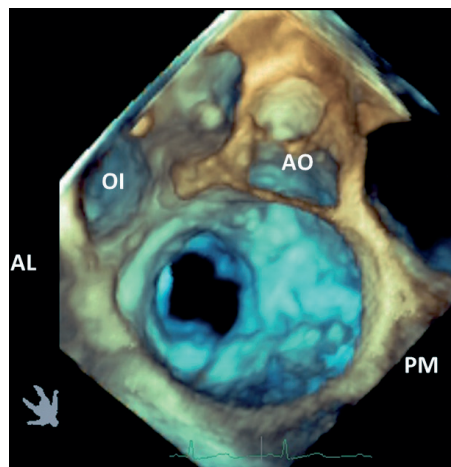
Three-dimensional transesophageal echocardiography. View from the left atrium in diastole: total fusion and lack of opening of the mitral valve posteromedial part. AL: Anterolateral. AV: Aortic valve. LAA: Left atrial appendage. PM: Posteriomedial.
